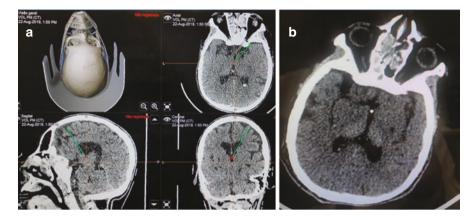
(a) Neuronavigation planning for catheter insertion into the third ventricle. (b) Postoperative computed tomography with catheter located at planned site
